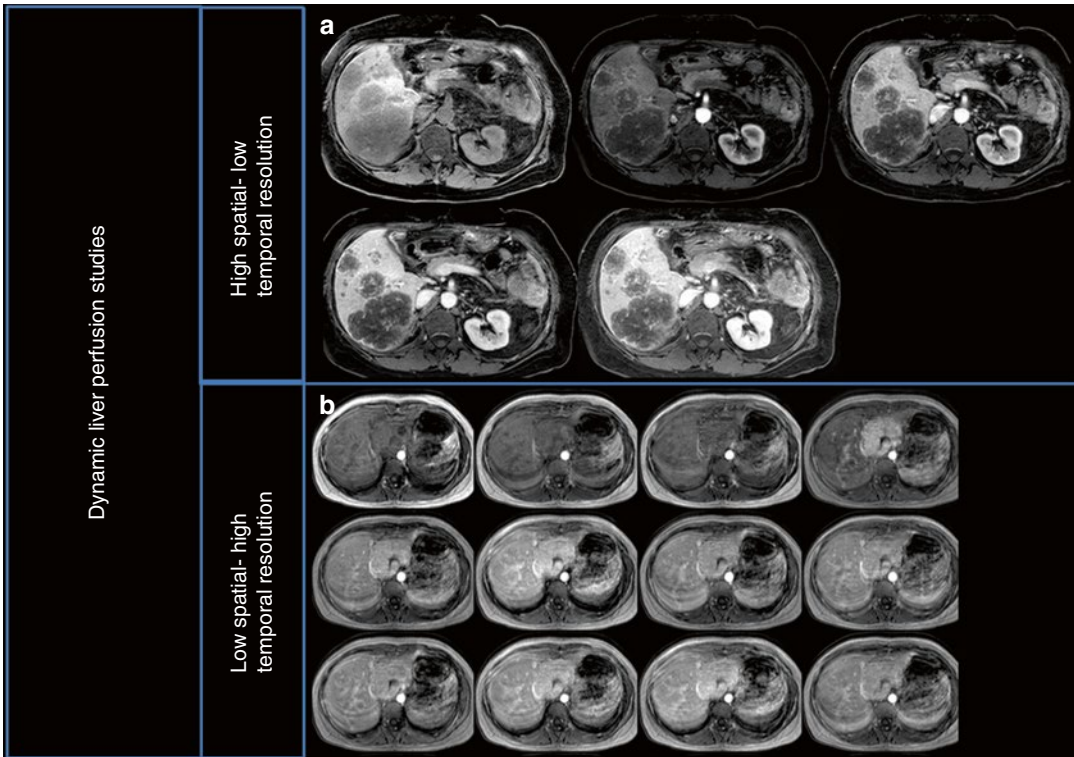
(a) Conventional liver DCE-MRI with low temporal resolution and high spatial one in a patient with liver metastases of colon adenocarcinoma. Five acquisitions (pre-contrast, arterial, portal, venous, and equilibrium phases) were acquired. Acquisition time per
